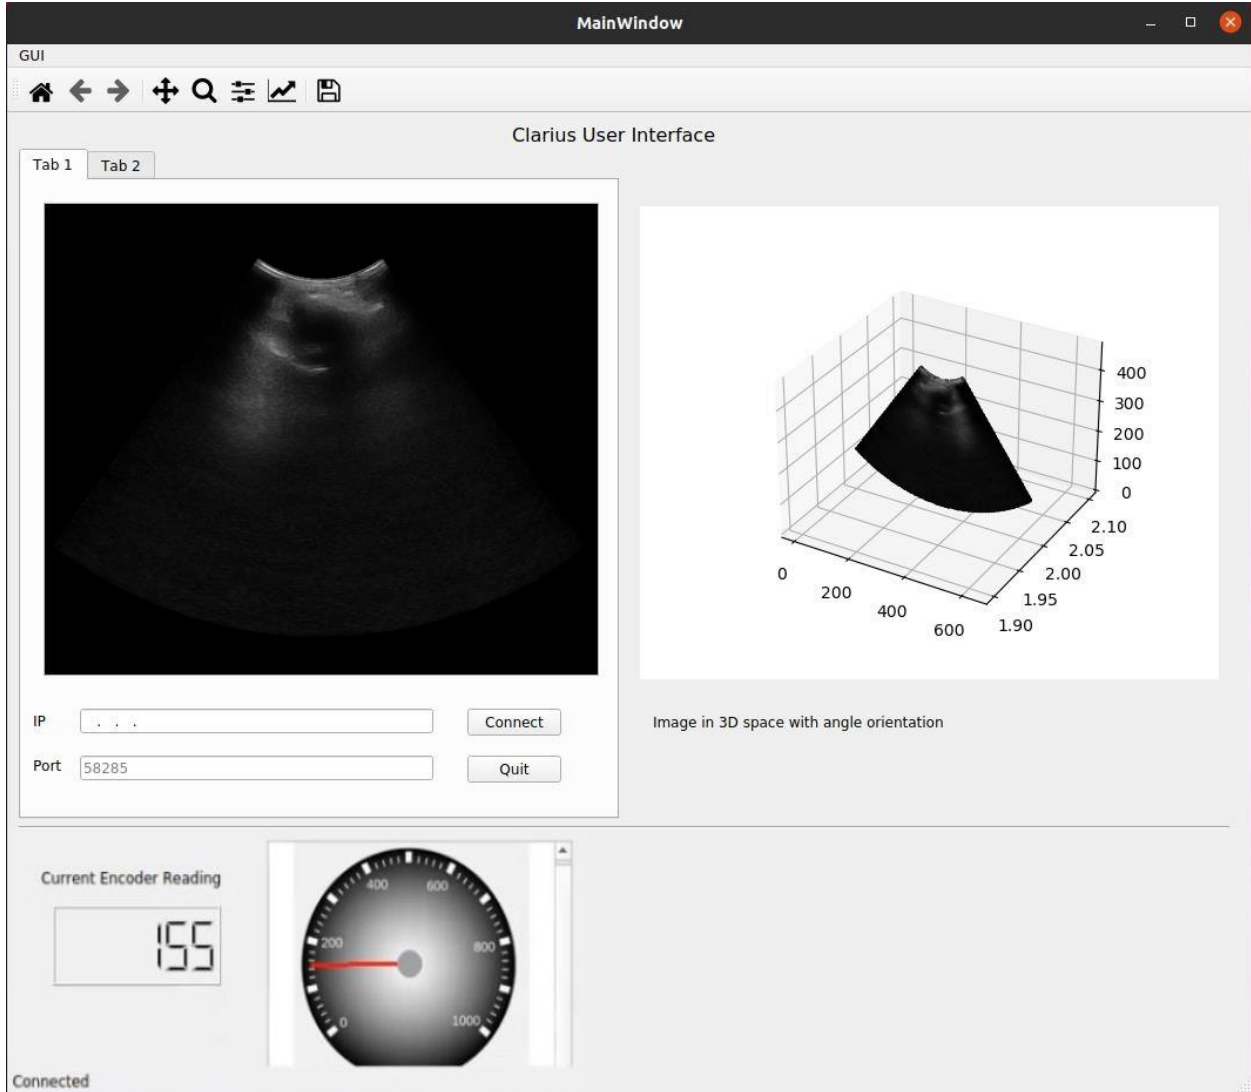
Ultrasound Image in 3D Space
